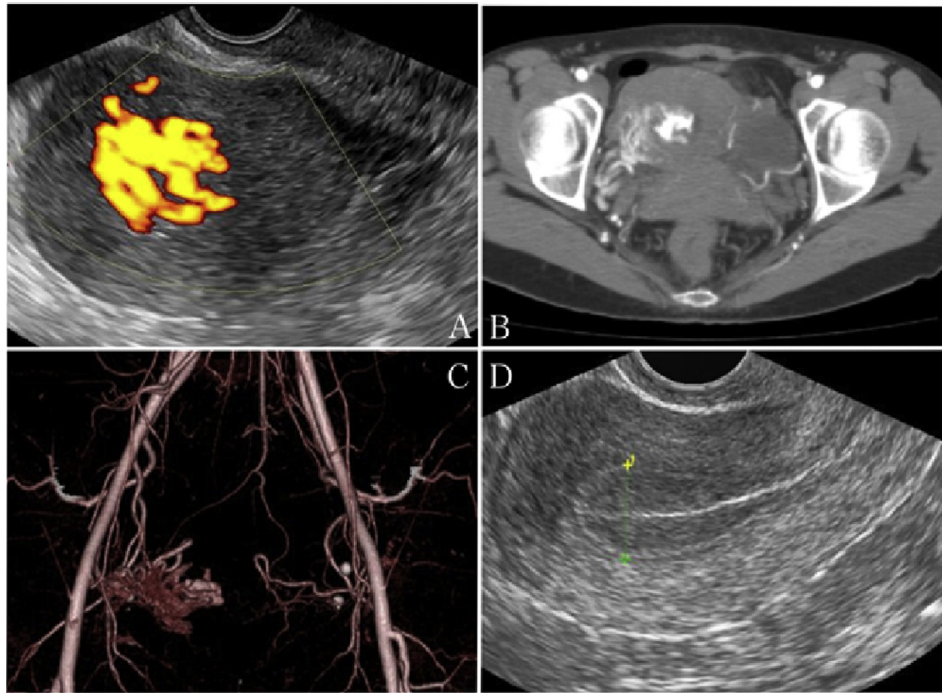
Preoperative and postoperative images of a patient with Power Doppler color score 4. (A) Doppler ultrasound on initial medical examination, (B) early arterial phase of dynamic contrast-enhanced computed tomography, (C) three-dimensional computed tomography angiography, and (D) transvaginal Doppler ultrasound after elimination of the placental polyp.
